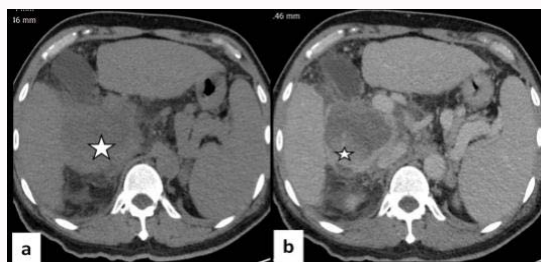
Computed Tomography abdomen findings: Non-Contrast Computed Tomography (NCCT) axial image (a) shows cirrhotic nodular liver, dilated splenic vein and splenomegaly. A hypodense lesion is seen in caudate lobe (*). Contrast Enhanced Computed Tomography (CECT) image (b) at same level shows thick enhancing wall and eccentric enhancing component (*) in the lesion.
